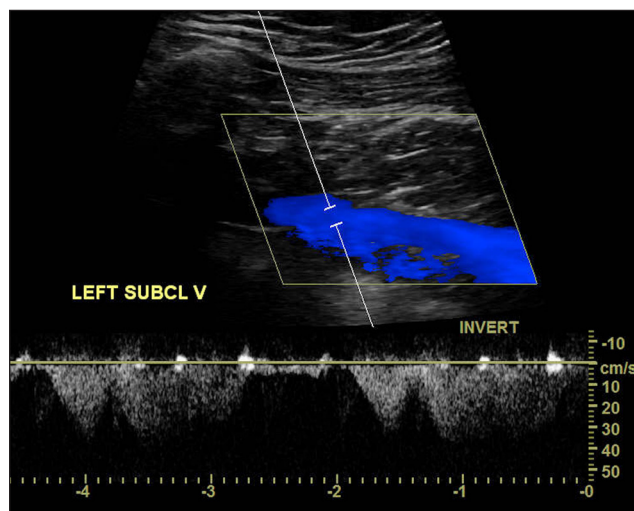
Venous duplex ultrasound of the left subclavian vein. Doppler image demonstrates normal blood flow and no detection of high intensity transient signals in the spectral Doppler.
